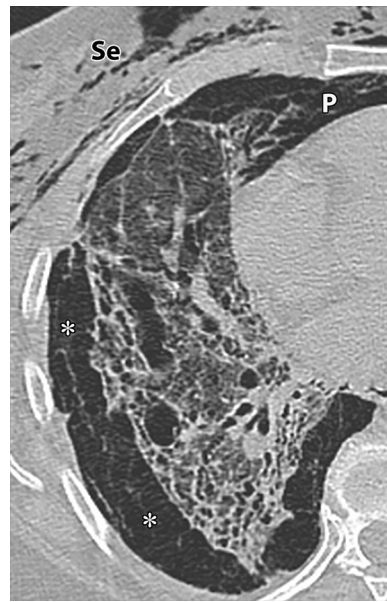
EPS air collection mimicking pneumothorax in a patient with idiopathic pulmonary fibrosis and sudden worsening of dyspnea. Axial CT image of the right side of the chest shows air (*) surrounding the lung and in continuity with pneumomediastinum (P). Web-like linear septa are present in the extrapleural air collection. Se = subcutaneous emphysema.
